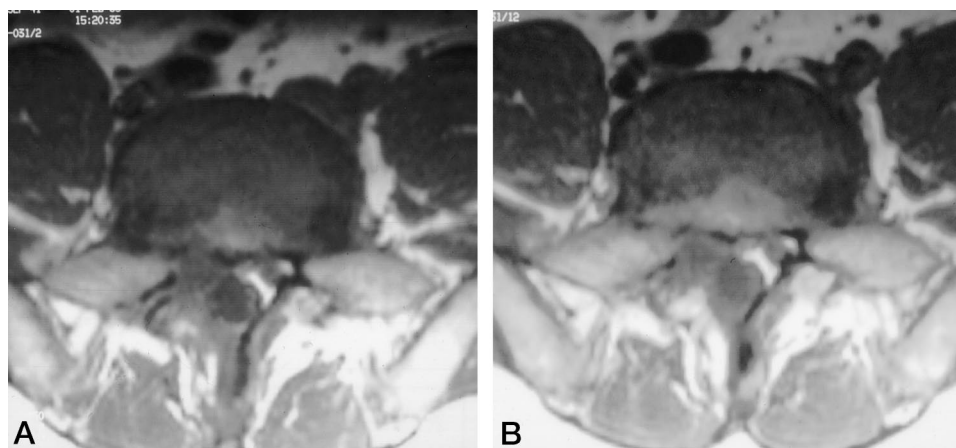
Axial T1-weighted images show right posterior grade-4 scar at 6 months (A), which changes to grade 2 at 12 months (B). The right anterior epidural space was grade 4 at both 6 and 12 months.
